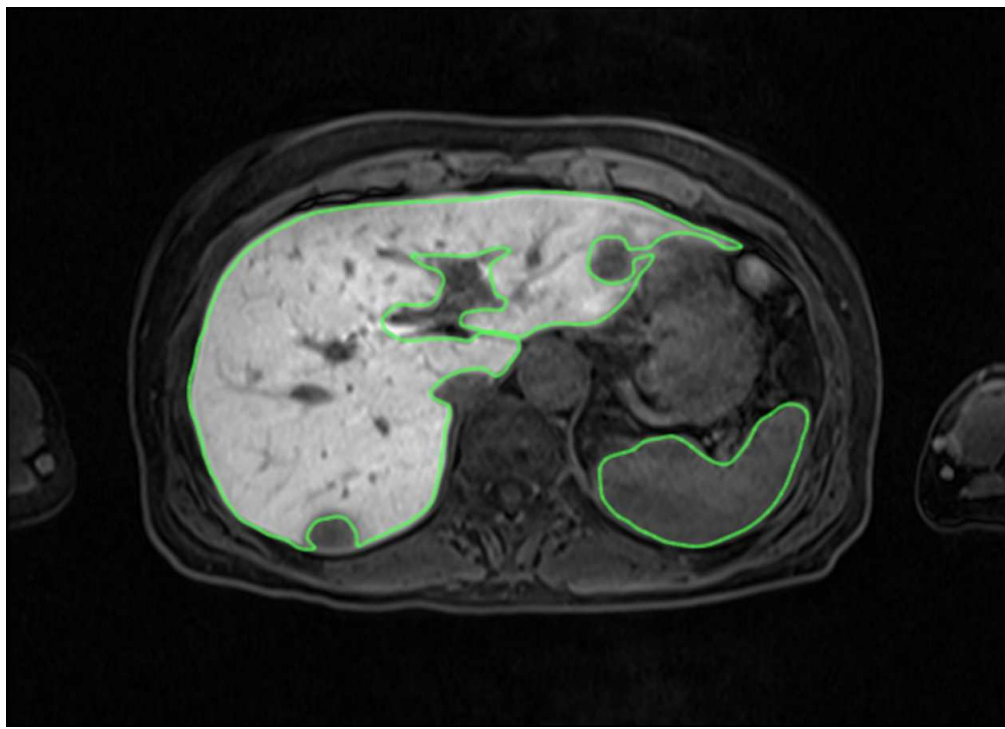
Case #23: A case with metastatic liver tumor: The contrast between the liver and spleen is high on gadxetate disodium-enhanced MR image. The background liver was proved to be normal liver by surgical resection. HUI is high (1.068) representing high ICG-PDR (0.207). The outlines of the liver and the spleen are shown by green lines.
